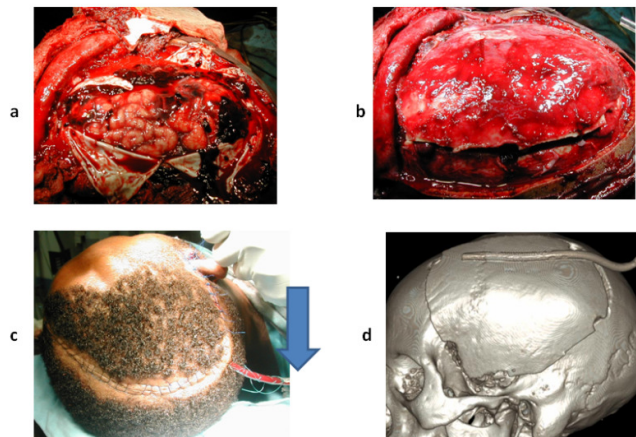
The Uribag wound drain following a major scalp dissection in a case of hinged decompressive craniectomy procedure using the temporalis muscle (14): (a, b) extensive scalp and intradural dissection with potential for postoperative surgical bed significant wound collection (c) the surgical site wound drain inserted at scalp wound closure, arrow (d) postoperative 3-D reconstructed image of the cranial CT scan showing the wound drain in-situ.
